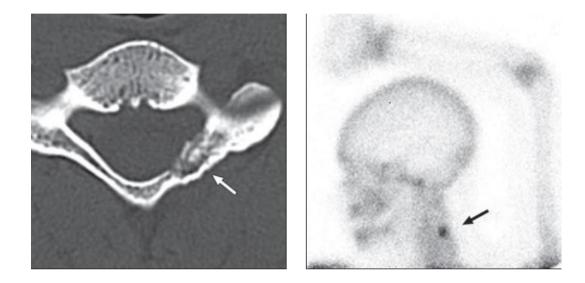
Osteoid osteoma - C4 left pars interarticularis. CT cervical spine shows oval lytic mildly expansile lesion (*arrow*) with central calcification in left posterior elements with mild sclerosis of adjacent facet. Left lateral view of cervical spine bone scan shows focal (*arrow*) radiotracer uptake, corresponding to tumor nidus.no double density sign (3).
